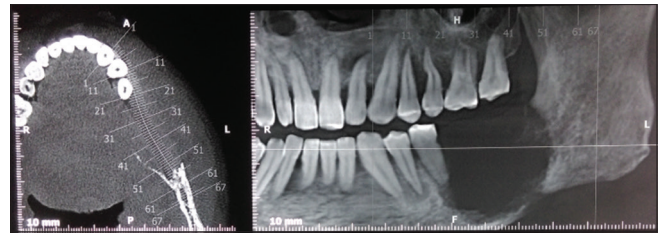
Cone-beam computed tomography revealed radiolucent lesion with ill-defined border
